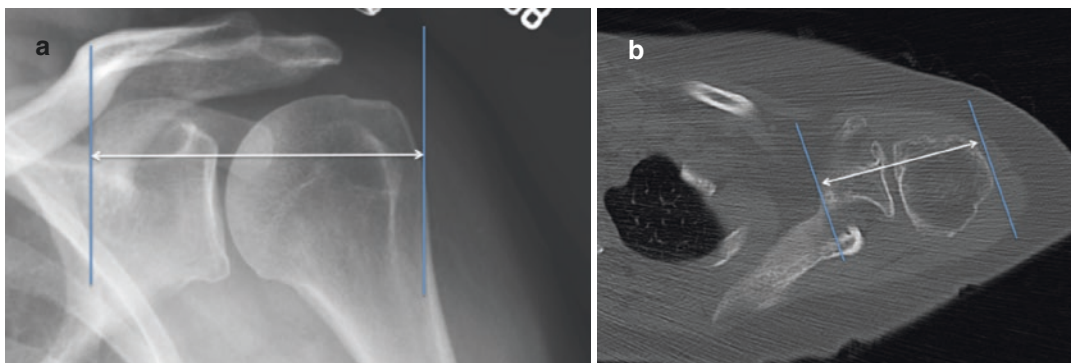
Lateral humeral offset. (a) AP radiograph of the left shoulder shows lateral humeral offset as distance (white line) between coracoid base and most lateral part of the greater tuberosity. (b) Axial CT image of the same
